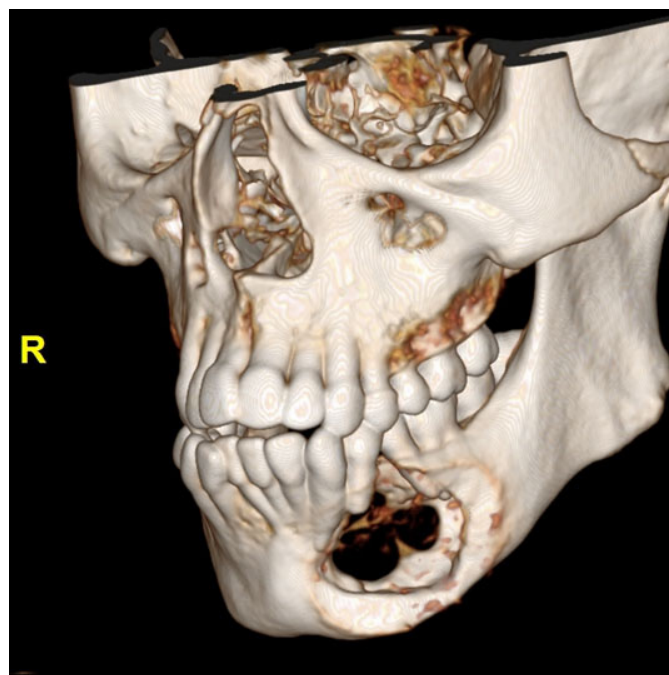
Computed tomography panorex without contrast showed diffusely increased density of bones with multiple expansile lytic lesions; largest lesion of 0.3 × 3.4 × 3.4 cm involved mandible.
